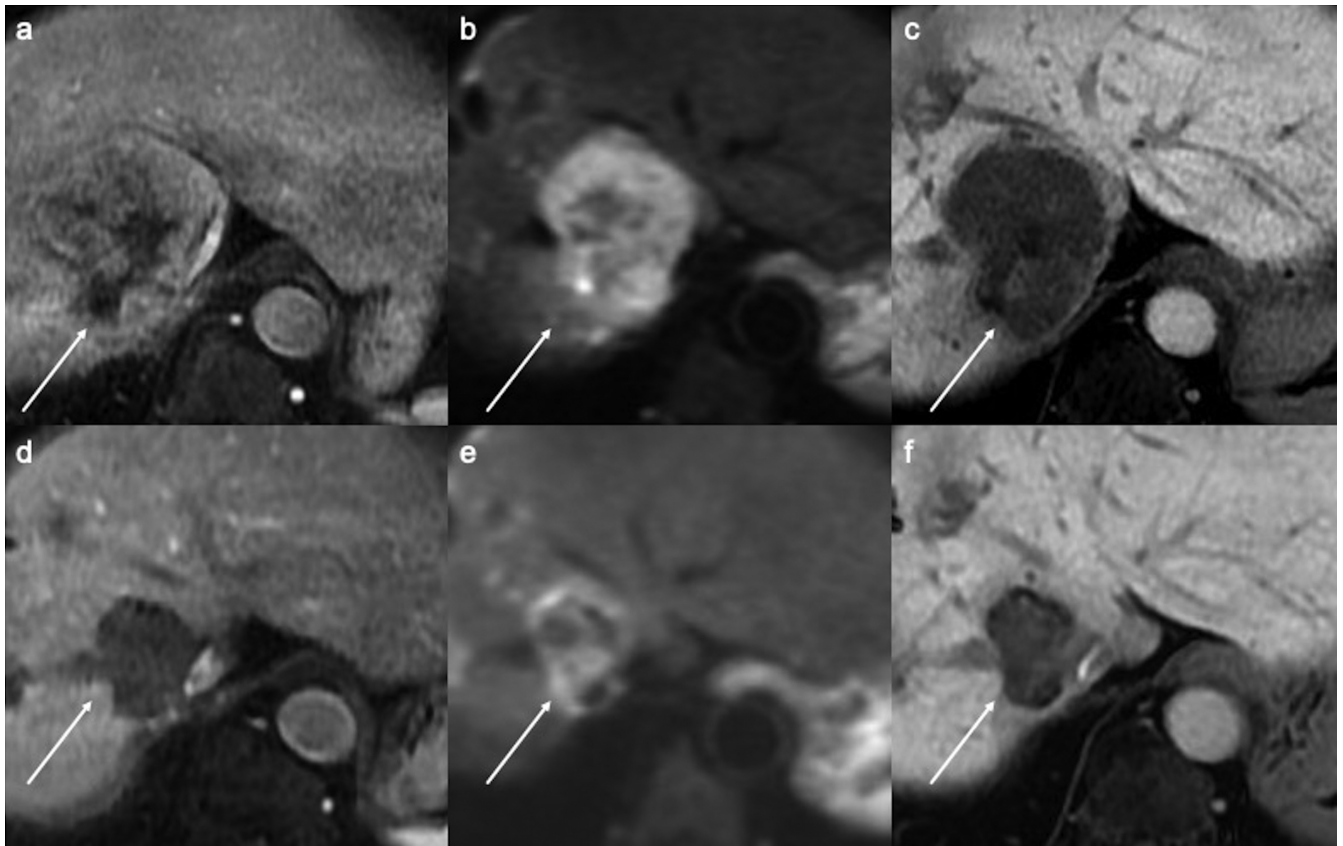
MR images from a 70-year-old female of hepatocellular carcinoma with extrahepatic spread (lymph node metastasis) treated with atezolizumab plus bevacizumab. The hepatic lesion showed the arterial phase hyperenhancement (a, arrow), restricted diffusion (b, arrow), and hypointensity in hepatobiliary phase (c, arrow) before the treatment. After 5 cycles of atezolizumab plus bevacizumab, the lesion became hypovascular and decreased in size, consistent with partial response according to RECIST (d-f, arrow). RECIST, response evaluation criteria in solid tumors.
